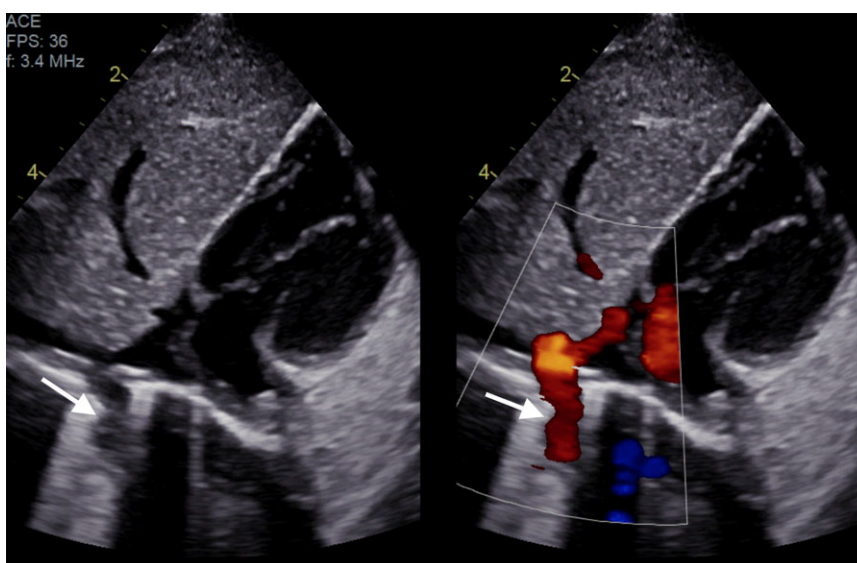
Transthoracic heart ultrasound revealing an anomalous drainage resulting from one vein originating in the lower portion of the right lung - scimitar vein (arrow) into the inferior vena cava.
